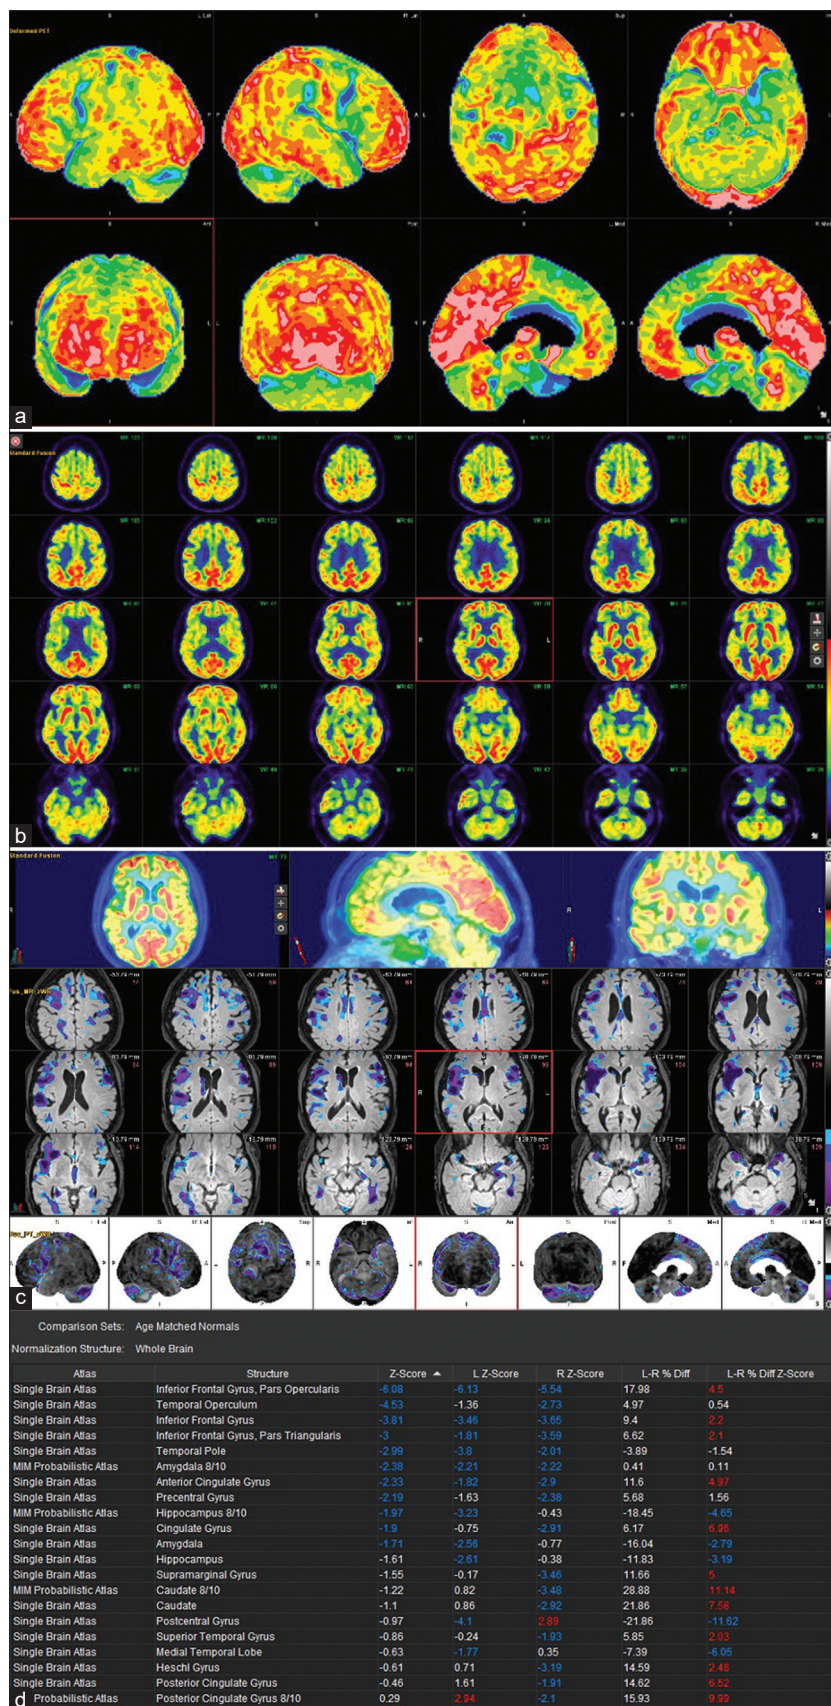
[<sup>18</sup>F]-fluorodeoxyglucose positron emission tomography/magnetic resonance imaging findings in a patient with right-dominant agrammatic variant primary progressive aphasia. (a) Cortical surface map. (b) Fusion [<sup>18</sup>F]-fluorodeoxyglucose positron-emission tomography and fluid-attenuated inversion recovery axial magnetic resonance imaging axial images. (c): Z-score overlay on cortical surface maps. (d) MIM Z score tabular output
